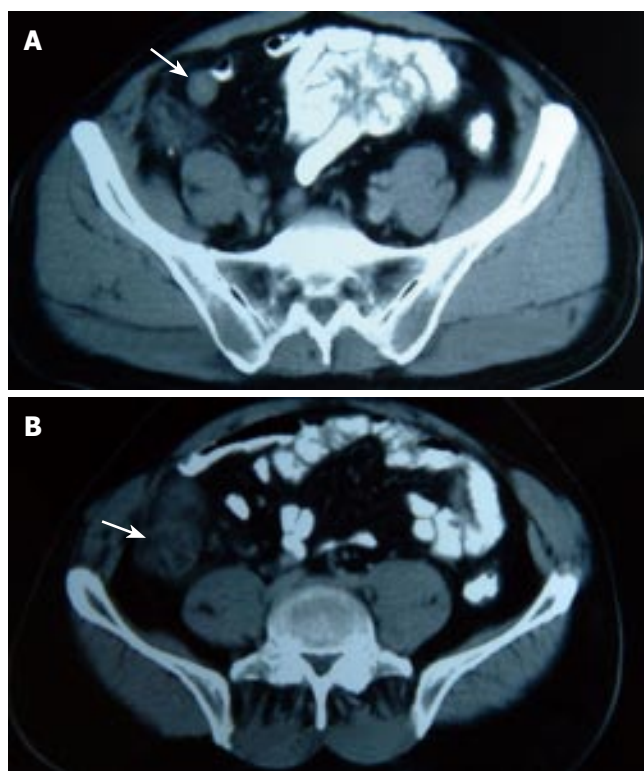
Contrast-enhanced CT scan of abdomen shows enlarged appendiceal stump with enhanced wall and local inflammatory changes (A) and distended cecum with thickening wall and stranding of adjacent mesenteric fat (B).
